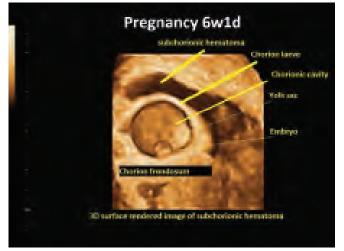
Three-dimensional transvaginal sonogram of the subchorionic hematoma in a close proximity to the gestational sac
